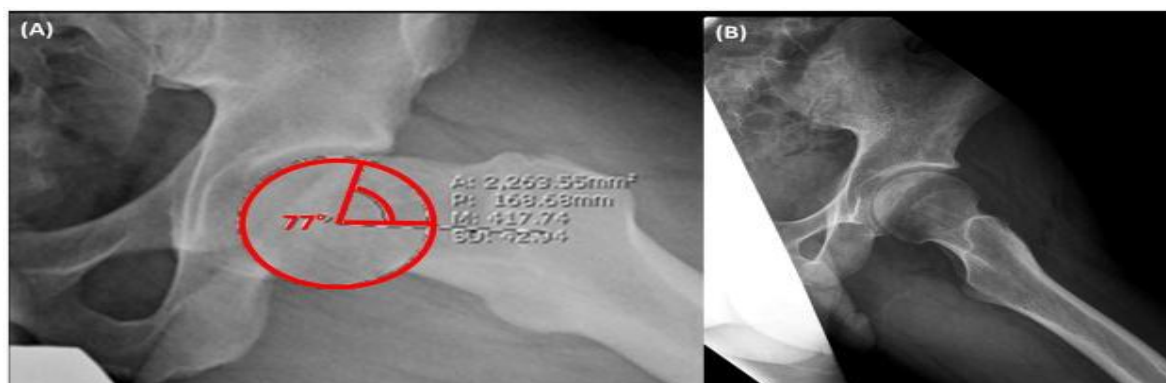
Lateral Hip Radiograph (A) 45° Dunn A lateral hip radiograph with measurement of the alpha angle. Firstly, the femoral neck axis is established as the line that connects the centre of the femoral head with the midpoint of the narrowest section of the femoral neck. Next, a circular shape is fitted to the head of the femur. The Alpha angle is determined by measuring the angle formed by the femoral neck axis and the line from the center of the circle to the precise location where the bony contour emerges outside the circle that best fits the data. Figure B: Frog Leg A lateral radiograph.
